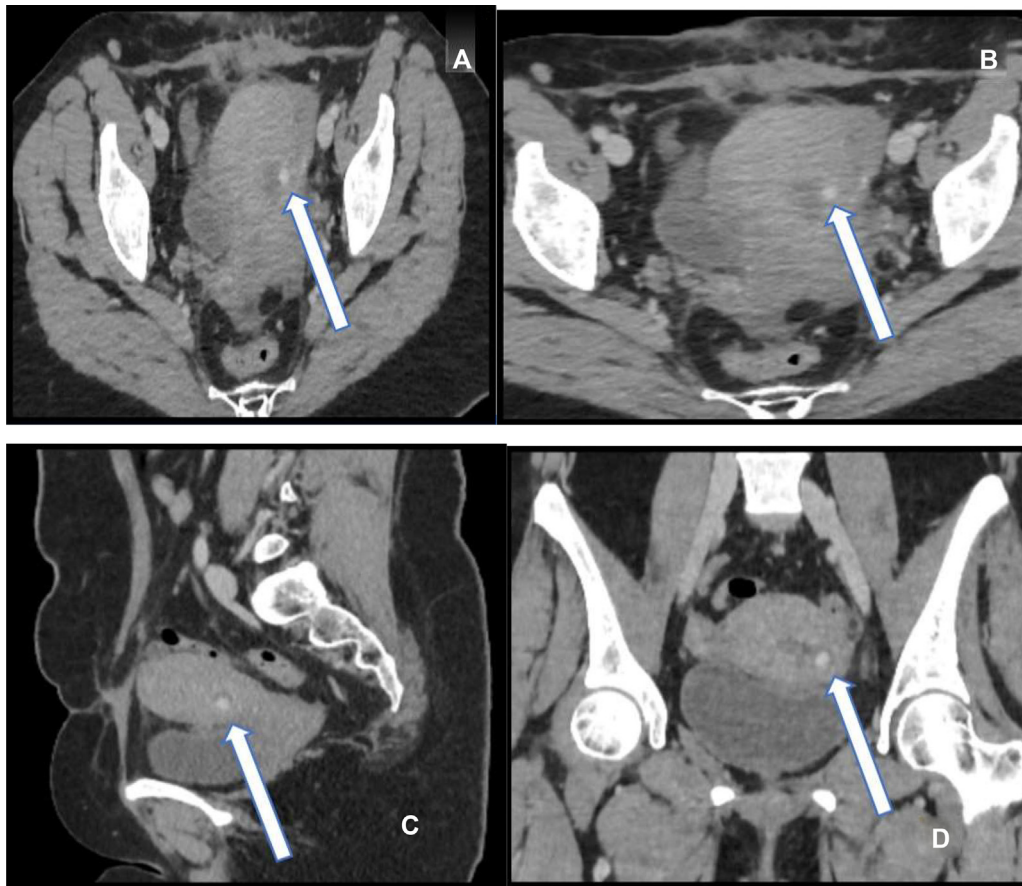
CT sections of the pelvis passing through the addition image corresponding to the pseudoaneurysm (white arrows) on axial (A) and (B), sagittal (C) and coronal (D) views.
